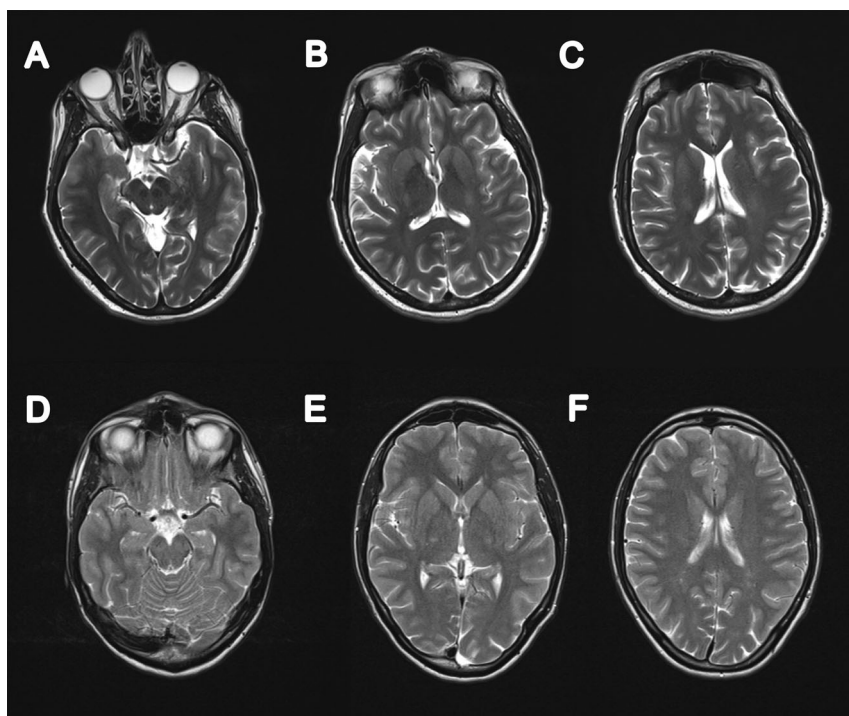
T2-weighted brain MRI for mother (A-C) and daughter (D-F), showing no relevant structural abnormalities.
